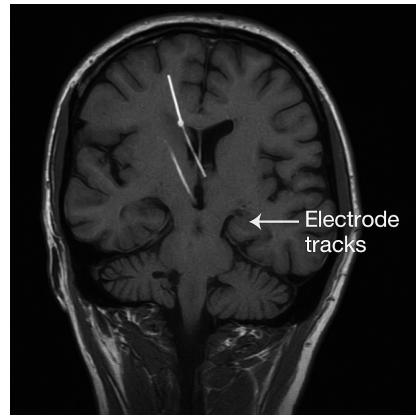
post-implant MRI scan
